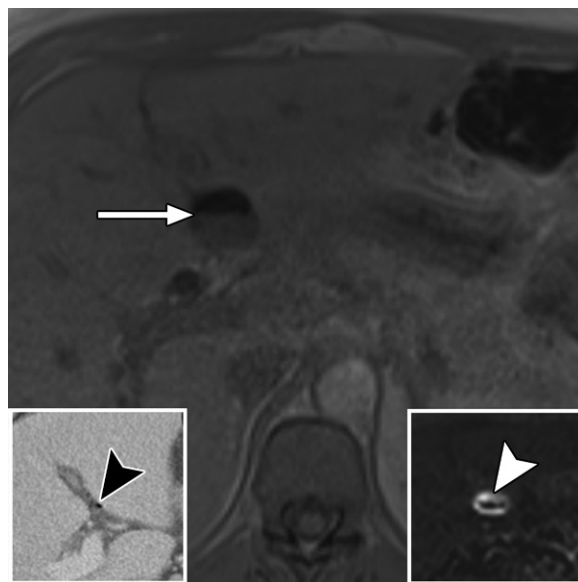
Pneumoperitoneum identified at MRI as magnetic susceptibility artifact in a 39-year-old woman with a perforated duodenal ulcer. A tiny locule of free air in the porta hepatis (black arrowhead) was not identified on the axial CT image (left inset). Subsequent axial in-phase MR image obtained a few days later shows an air-fluid level (arrow) in the porta hepatis, with corresponding hyperintense signal (white arrowhead) on the R2* map (right inset) generated from multiecho gradient imaging consistent with pneumoperitoneum. Exploratory laparotomy confirmed a perforated duodenal ulcer.
